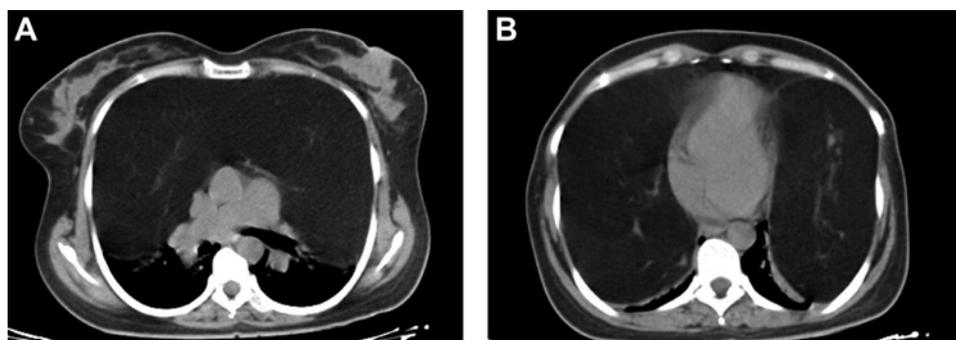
(A, B) Axial non-contrast CT showing fatty symmetrical masses in the mediastinum.
